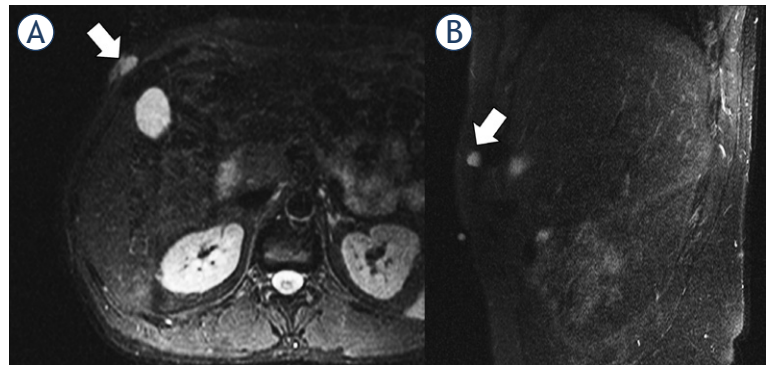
1.5-T MRI of the abdomen (A) contrast-enhanced T1 axial, (B) contrast-enhanced T1 sagittal) of a 41-year-old patient. The low-grade sarcoma in the right abdominal wall (white arrow) presents with a ovoid/nodular configuration.
